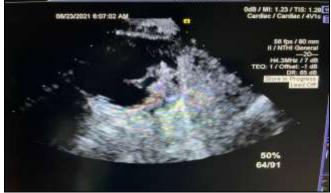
Post procedure Echocardiography showing both Pulmonary and Aortic end of ADO-II
